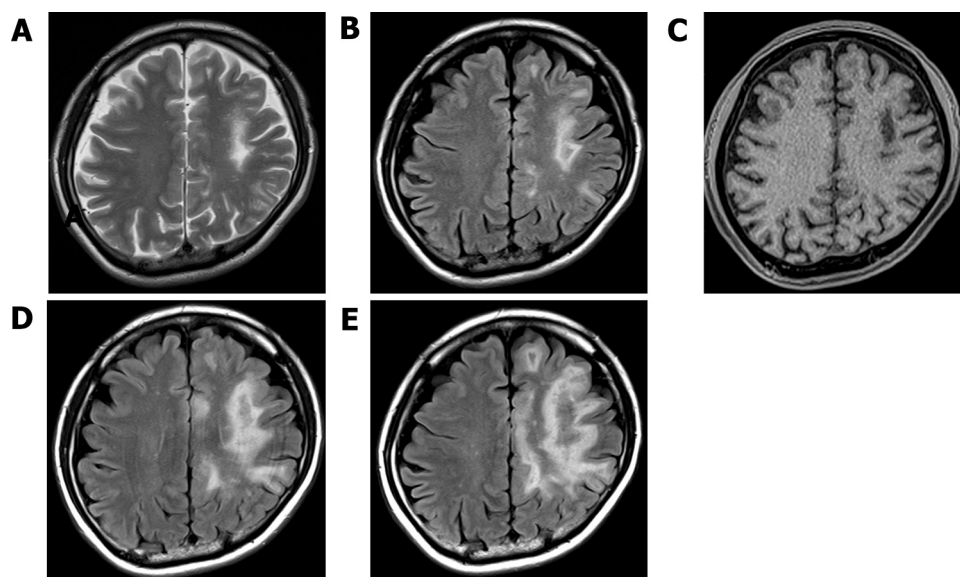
Initial magnetic resonance imaging (MRI) of the brain demonstrated high T2 signals (A) and high FLAIR signals (B) with low T1 signals (C) in the subcortical white matter of the left frontal parietal lobe. No mass lesions with contrast enhancement are present. High FLAIR signals 28 days after admission (D) and 53 days after admission (E). Increases in high-signal intensity are observed over time.
